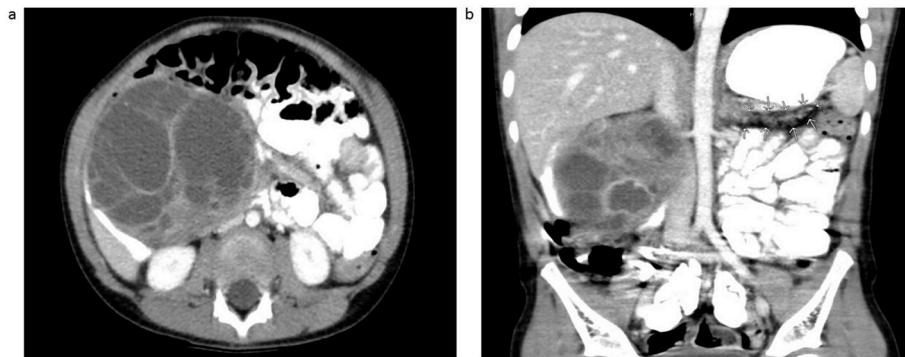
(a) CT Abdomen and Pelvis axial demonstrating large multiseptated cystic mass in the right-upper quadrant. (b) coronal section showing accompanying atrophy in the tail of the pancreas.
